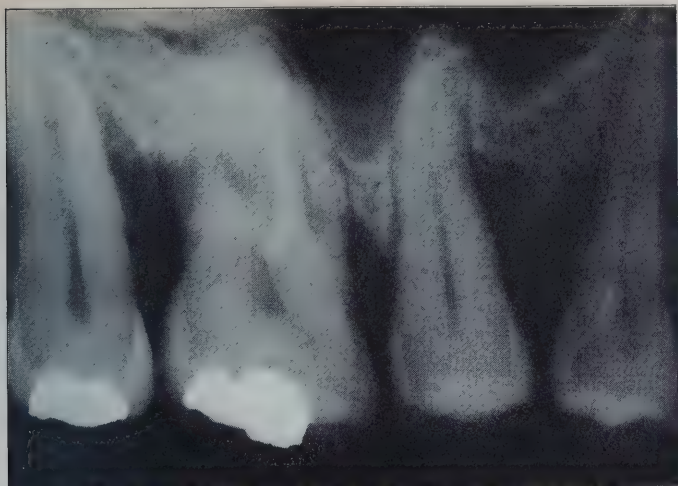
Radiograph of the maxillary right posterior region depicting vertical bone loss.
